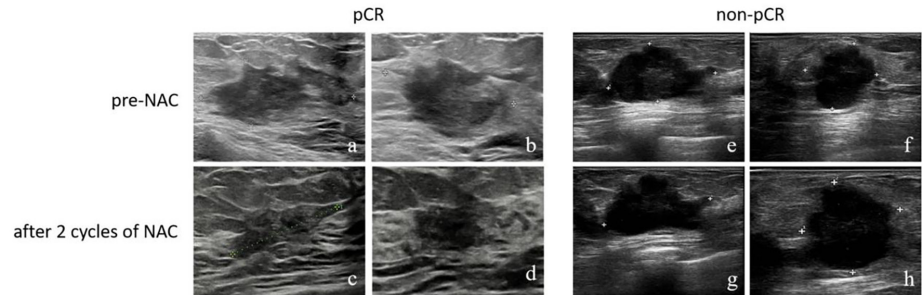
Grey-scale US images. (a, b) The three largest tumor dimensions in the transverse and longitudinal images before NAC. (c, d) The three largest tumor dimensions in the transverse and longitudinal images after two cycles of NAC. The patient completed neoadjuvant systemic therapy, and surgical pathology confirmed a pCR. (e, f) The three largest tumor dimensions in the transverse and longitudinal images before NAC. (g, h) The three largest tumor dimensions in the transverse and longitudinal images after two cycles of NAC. The patient completed neoadjuvant systemic therapy, and surgical pathology confirmed a non-pCR. US, ultrasound; NAC, neoadjuvant chemotherapy; pCR, pathologic complete response.
